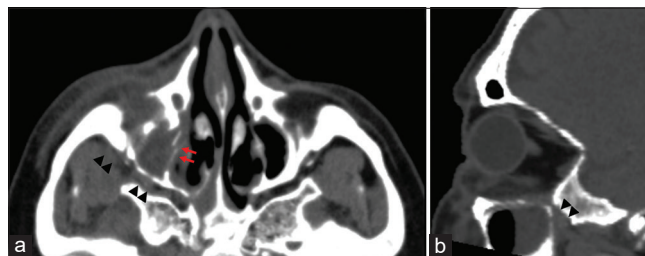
Sinus computed tomography (CT) scan at the clinical onset. Axial (a) and sagittal (b) CT scan examination with soft-tissue algorithm showing right maxillary invasive sinusitis. Note focal sinus medial wall discontinuities (red arrows in a) and partial obliteration of normal fat planes in the pterygomaxillary fissure (arrowheads in a and b).
